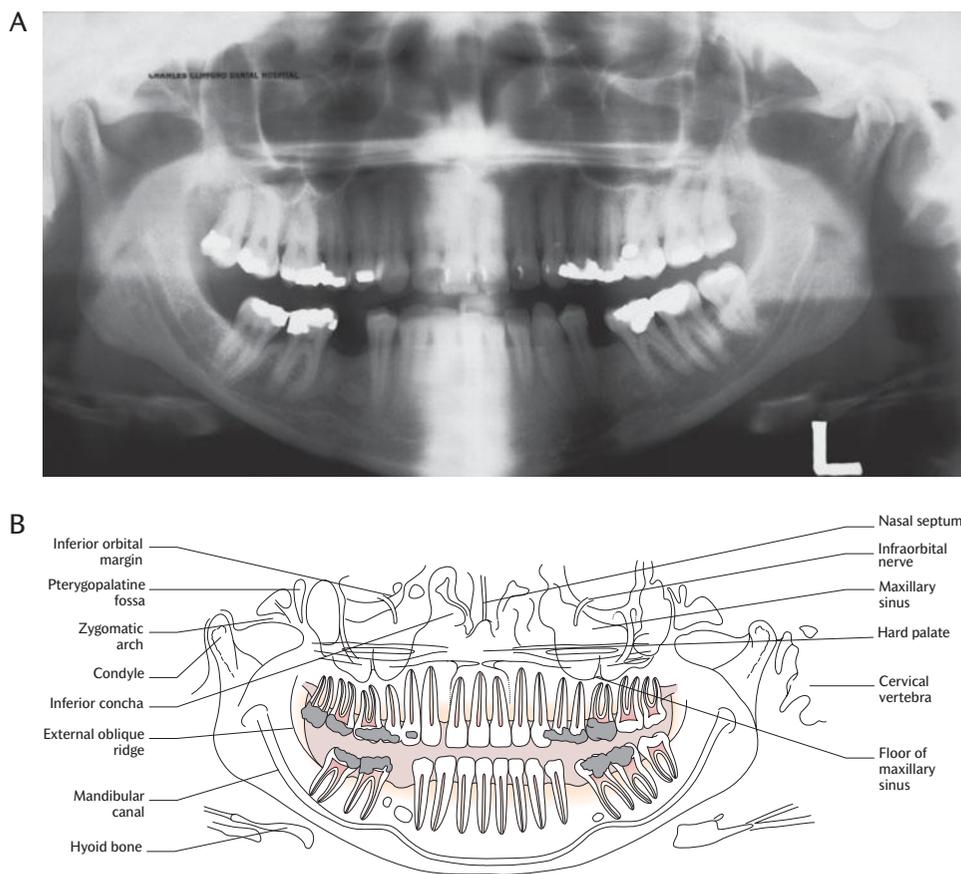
A) A panoramic radiograph; B) Key.
